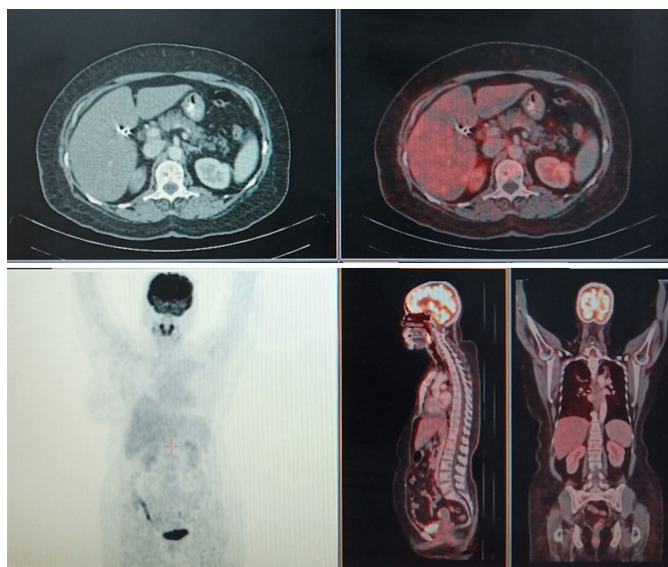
PET-CT (May 2019) showing complete resolution of the disease.
